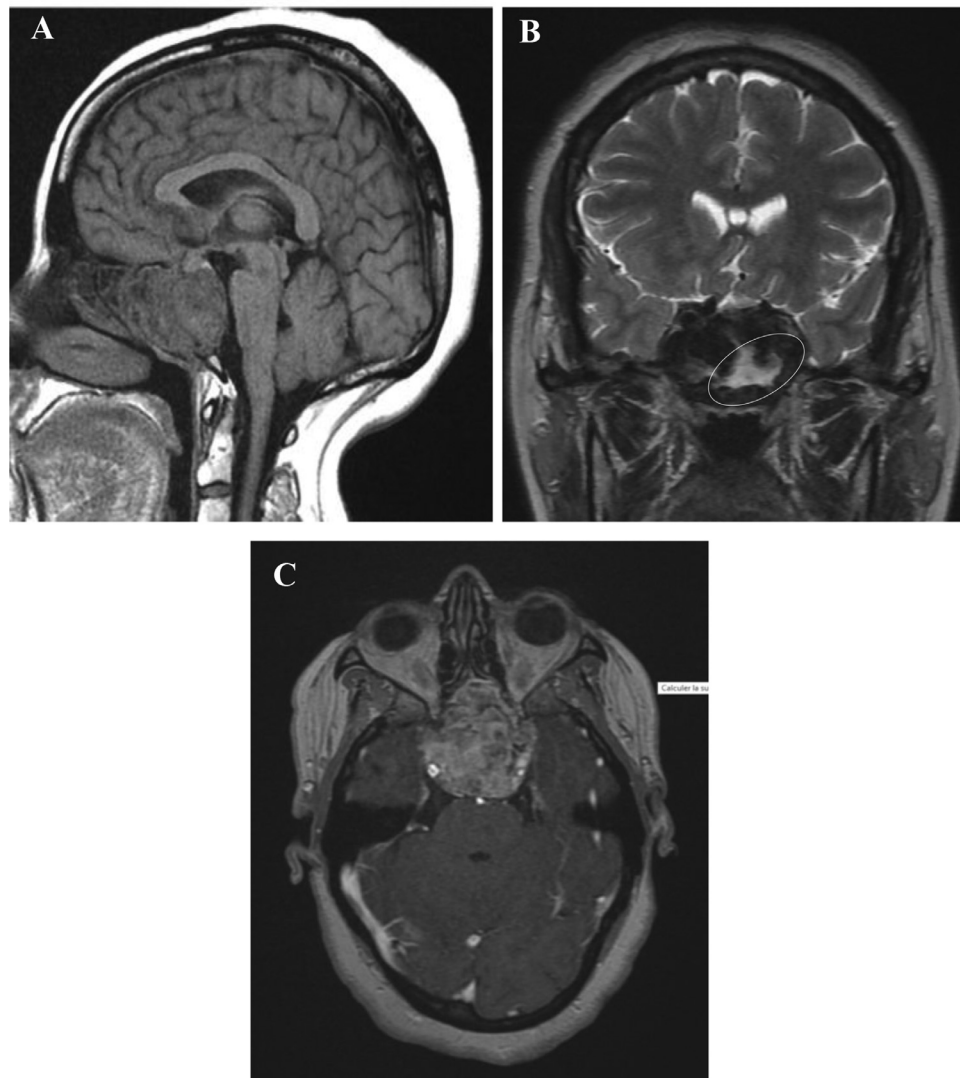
Initial MRI scan: A (Sagittal T1), B (Coronal T2), C (axial T1 C+) showing the extensions of a sphenoid mass (white arrow), with low signal T2, isosignal T1 and heterogeneous enhancement post-administration of contrast agent. Note the large cystic component on T2-WI (white circle).
